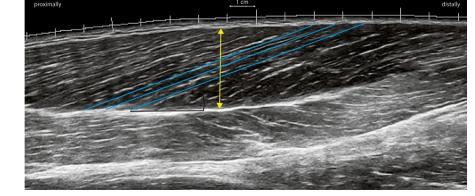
Example of extended field-of-view ultrasound image of long head biceps femoris. Measured parameters: muscle thickness (yellow arrow), fascicle length (blue solid lines), and pennation angle (black curved line)
